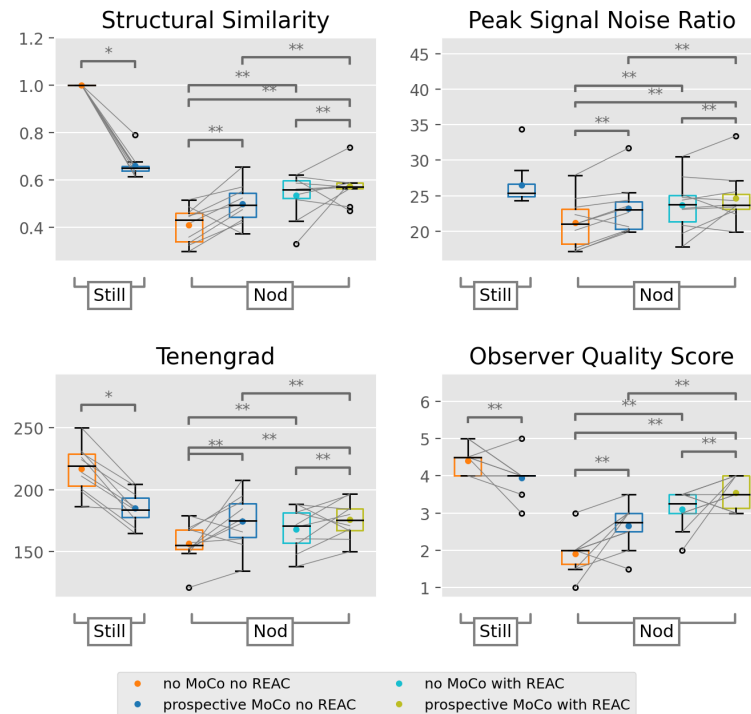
Comparison of image quality metrics SSIM, PSNR and Tenengrad, as well as observer quality scores for T<sub>2</sub> FLAIR scans with and without pMC as well as reacquisition. All metric values are markedly increased for scans with reacquisition (cyan and green). The largest improvement is observed for the combination of reacquisition and motion correction (green), which clearly outperforms the clinical standard (orange, please consult the caption of Figure 34 for figure details).
